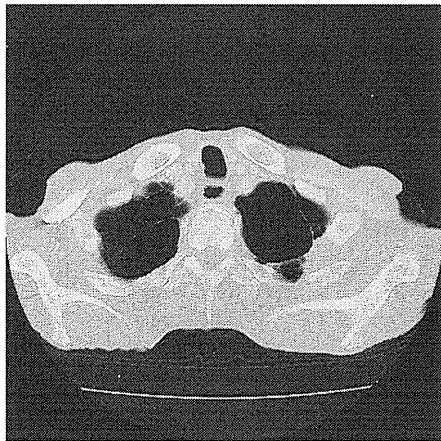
CT scan revealed the lung mass.
